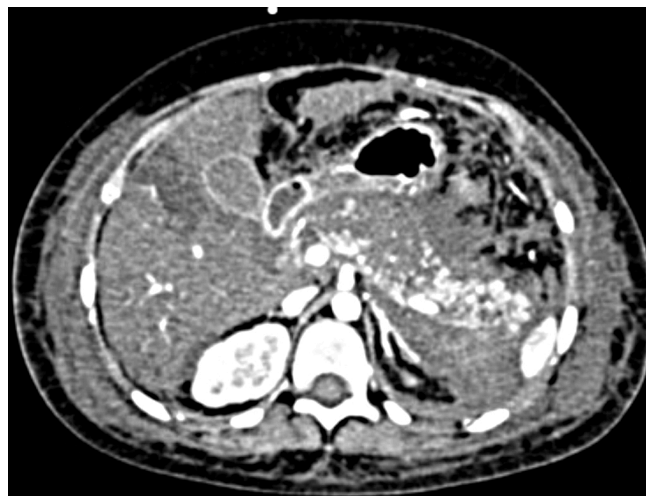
CT scan of the abdomen showing necrotic pancreatic lesions.
